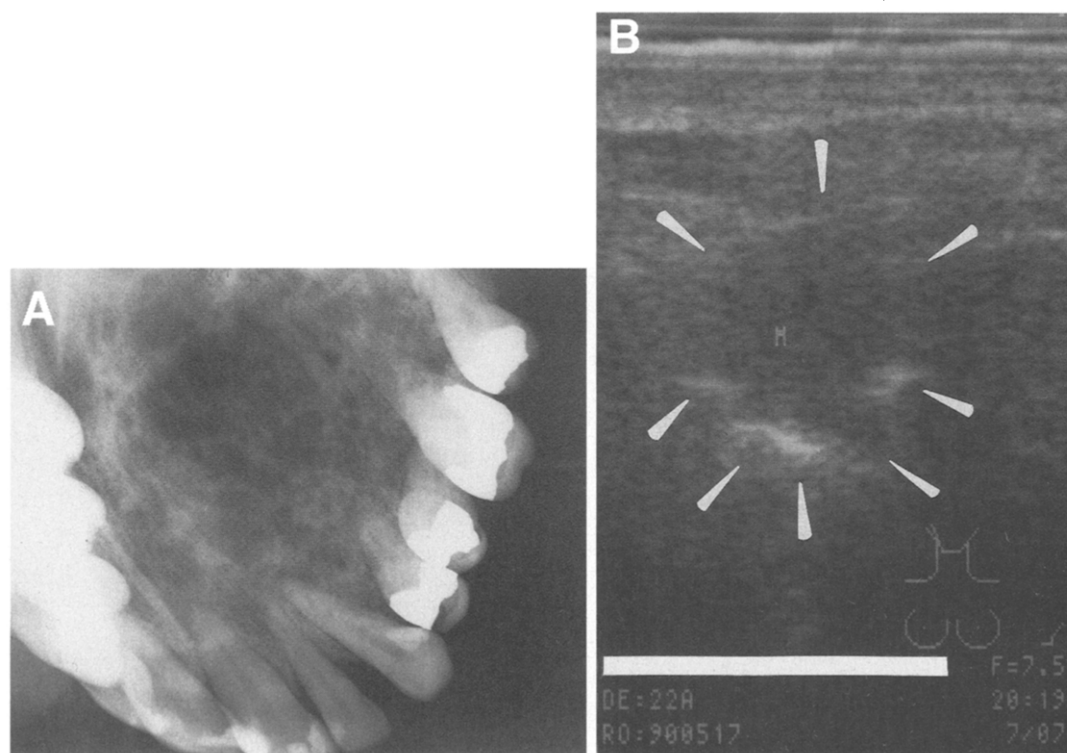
A, Occlusal radiograph of follicular ameloblastoma of left maxilla of 38-year-old white man. Lesion shows well-defined multilocular radiolucent image causing teeth displacement. B, US image of same lesion shows hyperechoic aspect characteristic of lesions with solid content (*arrows*).
